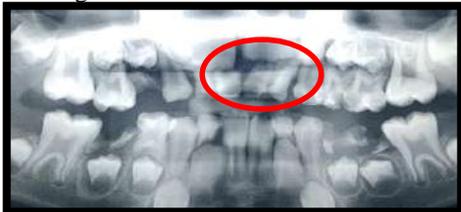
Previous panoramic radiograph i.e 6 months Old
